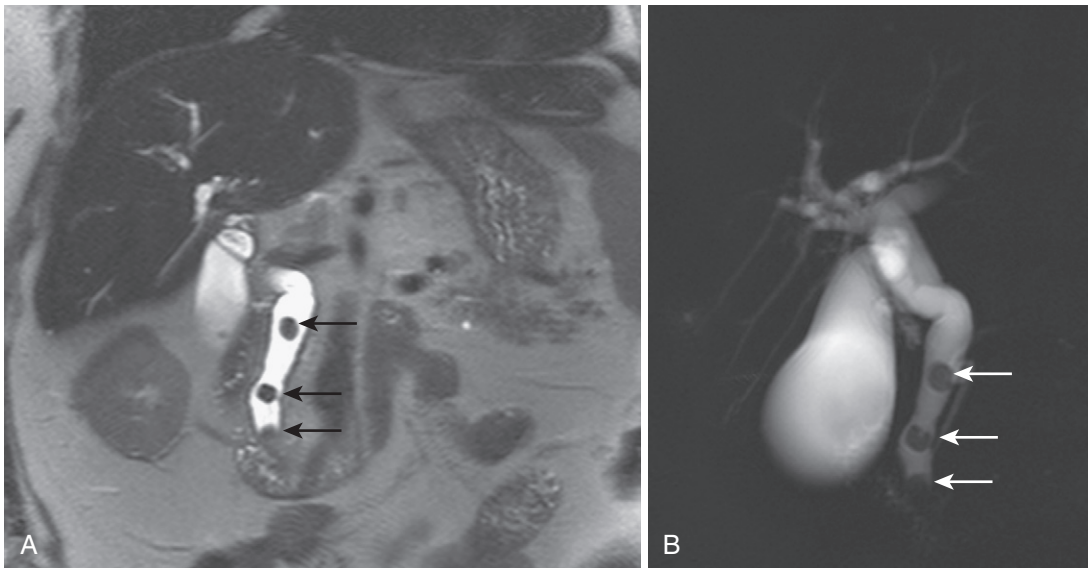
Choledocholithiasis. A, The coronal heavily T2-weighted image shows three filling defects (*arrows*) in the dilated CBD. B, The thick-slab MRCP image yields a more comprehensive appraisal of the biliary tree, showing choledocholithiasis (*arrows*) and the full extent of intra- and extrahepatic biliary dilatation.
